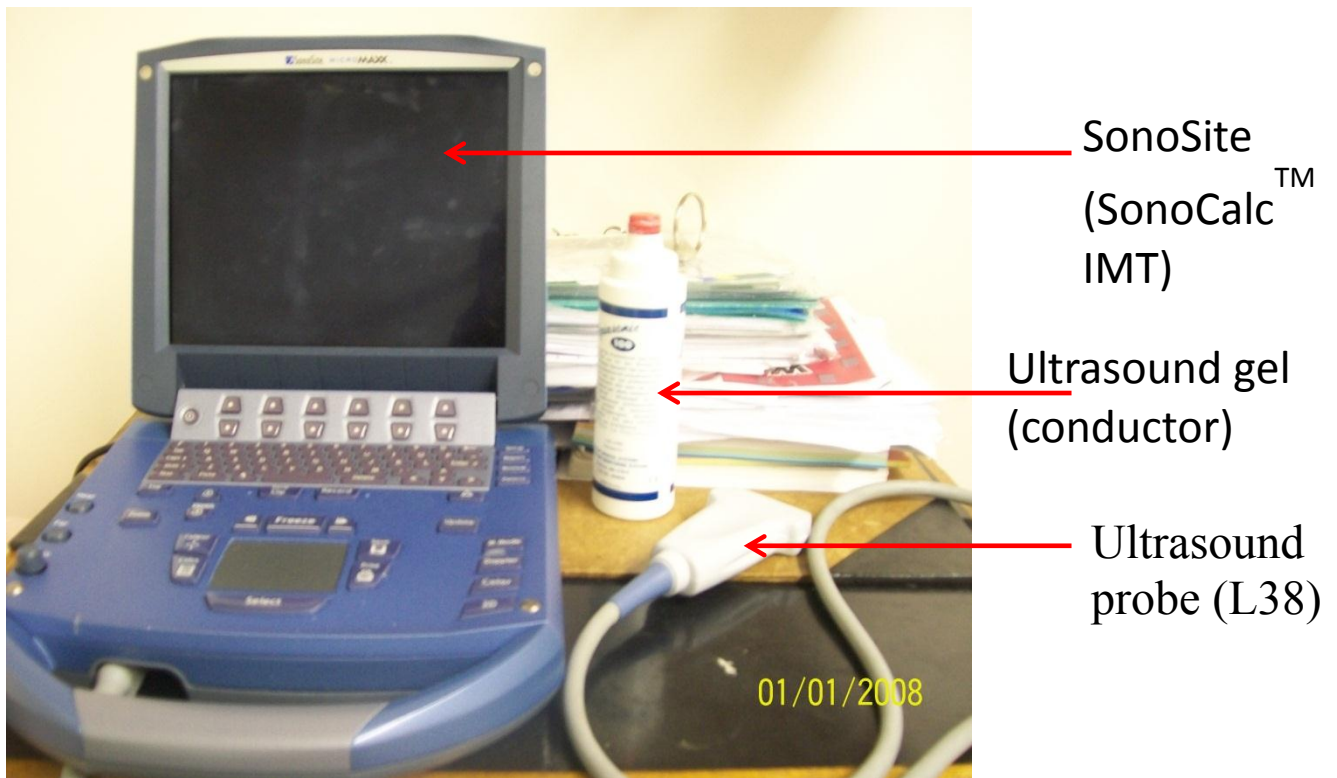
The SonoSite (SonoCalc™ IMT) version 3.4ultrasound MicroMaxx system with linear probe and ultrasound gel.
